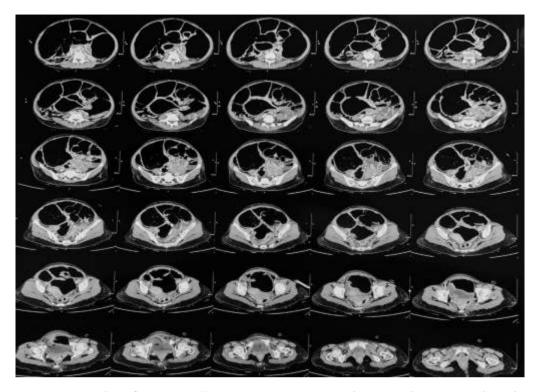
a. & b. Abdominal Computed Tomography scan showing massive bowel dilatation with no mechanical obstruction
